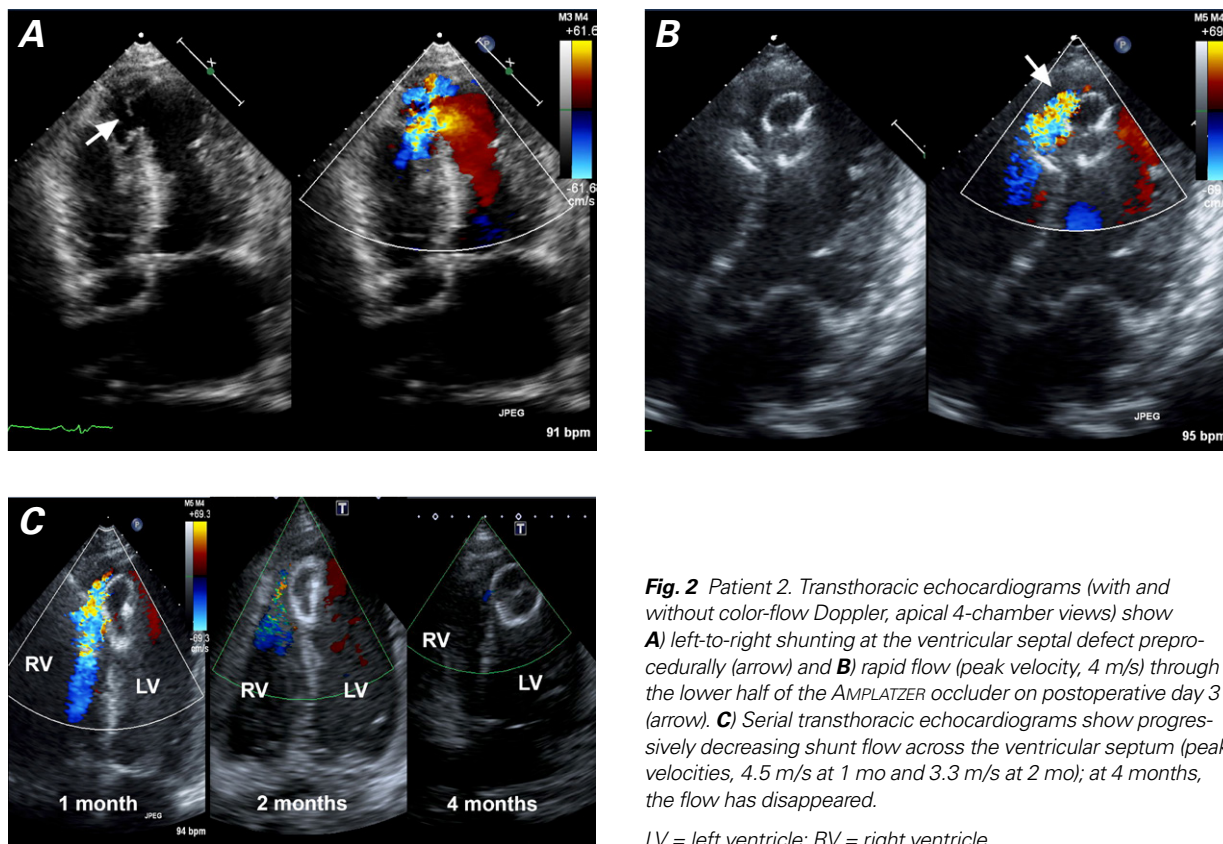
Patient 2. Transthoracic echocardiograms (with and without color-flow Doppler, apical 4-chamber views) show A) left-to-right shunting at the ventricular septal defect pre-procedurally (arrow) and B) rapid flow (peak velocity, 4 m/s) through the lower half of the AMPLATZER occluder on postoperative day 3 (arrow). C) Serial transthoracic echocardiograms show progressively decreasing shunt flow across the ventricular septum (peak velocities, 4.5 m/s at 1 mo and 3.3 m/s at 2 mo); at 4 months, the flow has disappeared.
